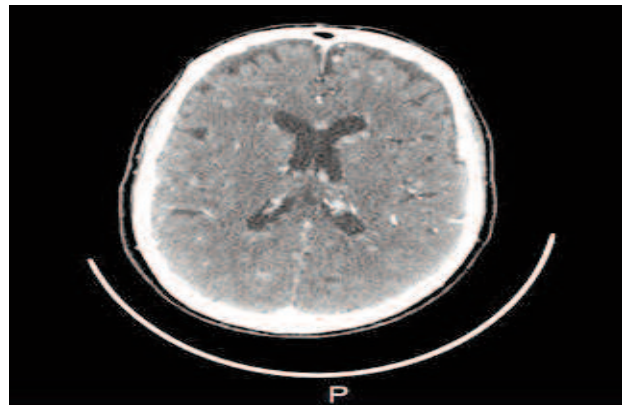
Cerebral CT scan: infracentimetric nodules with contrast enhancement.
